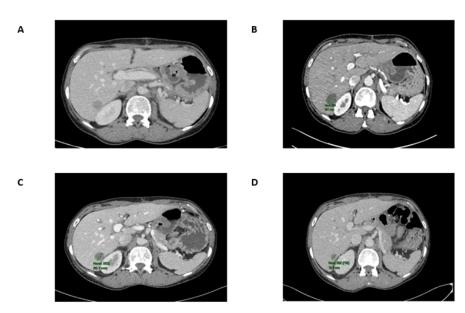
A) Computed tomography at diagnosis, B) after 3 months, C) after 6 months, D) and after 12 months of treatment with everolimus and lenvatinib.
